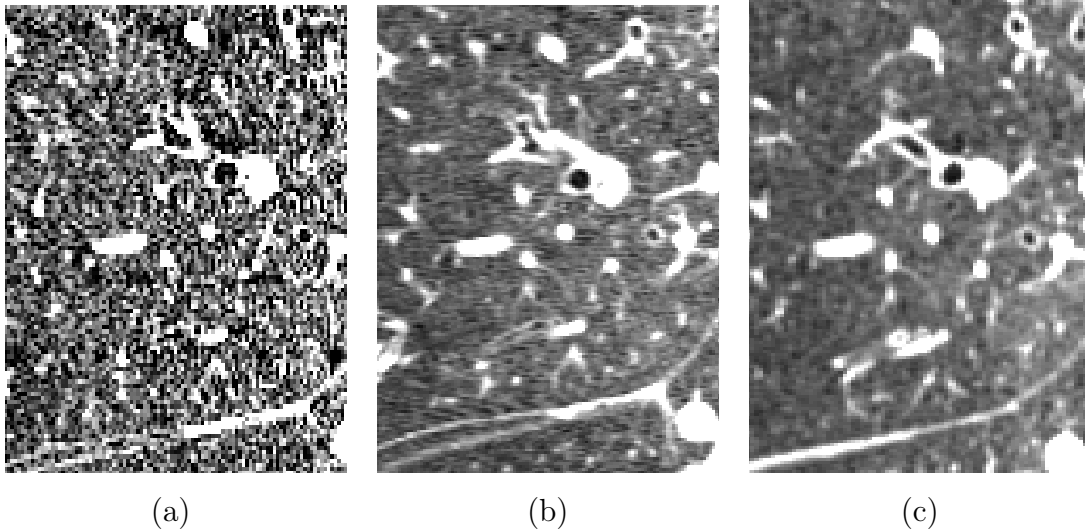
Coronal views of a small lung region for a single subject on three CT scans acquired with different imaging protocols: (a) EMCAP B60f (sharp) from 2007, (b) EMCAP B31f (smooth) from 2008, and (c) MESA COPD from 2009.*
